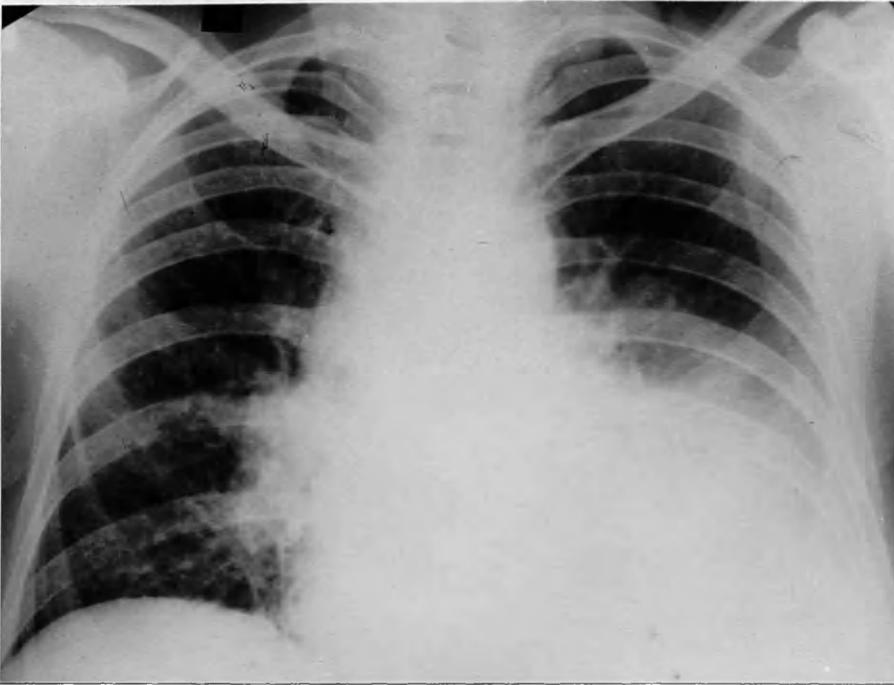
Chest X-ray in patient M.M. with chronic myeloid leukaemia.
